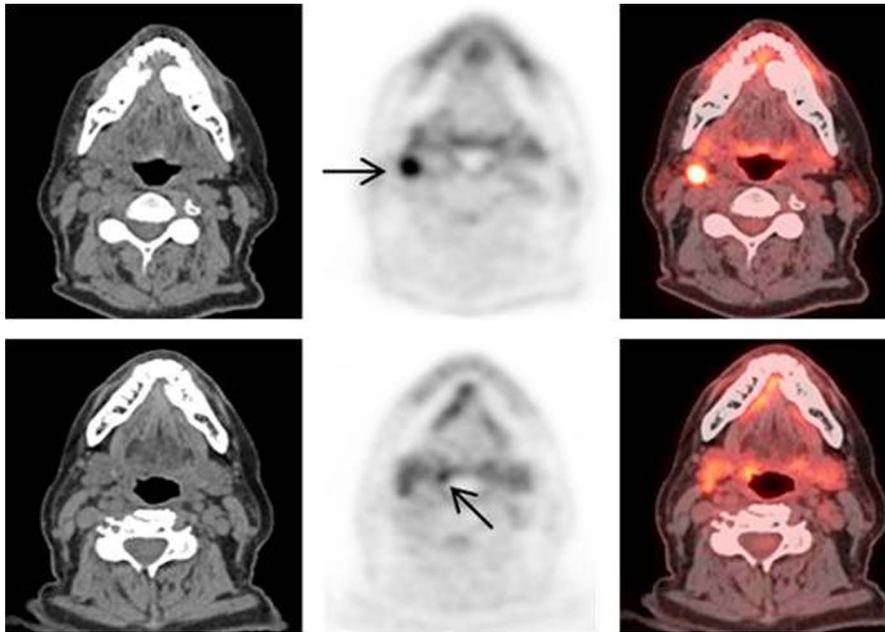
Staging–detection of unknown primary. A 67-year-old man, who underwent a thyroid ultrasound demonstrated 1.1 cm right level II lymph node. Fine-needle aspiration results from the right level II node found to be positive for poorly differentiated SCC. ^{18}F -FDG PET/CT scan demonstrates focal FDG uptake at the right glossotonsillar sulcus, proven to be a site of primary tumor and FDG-avid right level II metastatic lymph node (cT1 cN1 M0, stage III).
